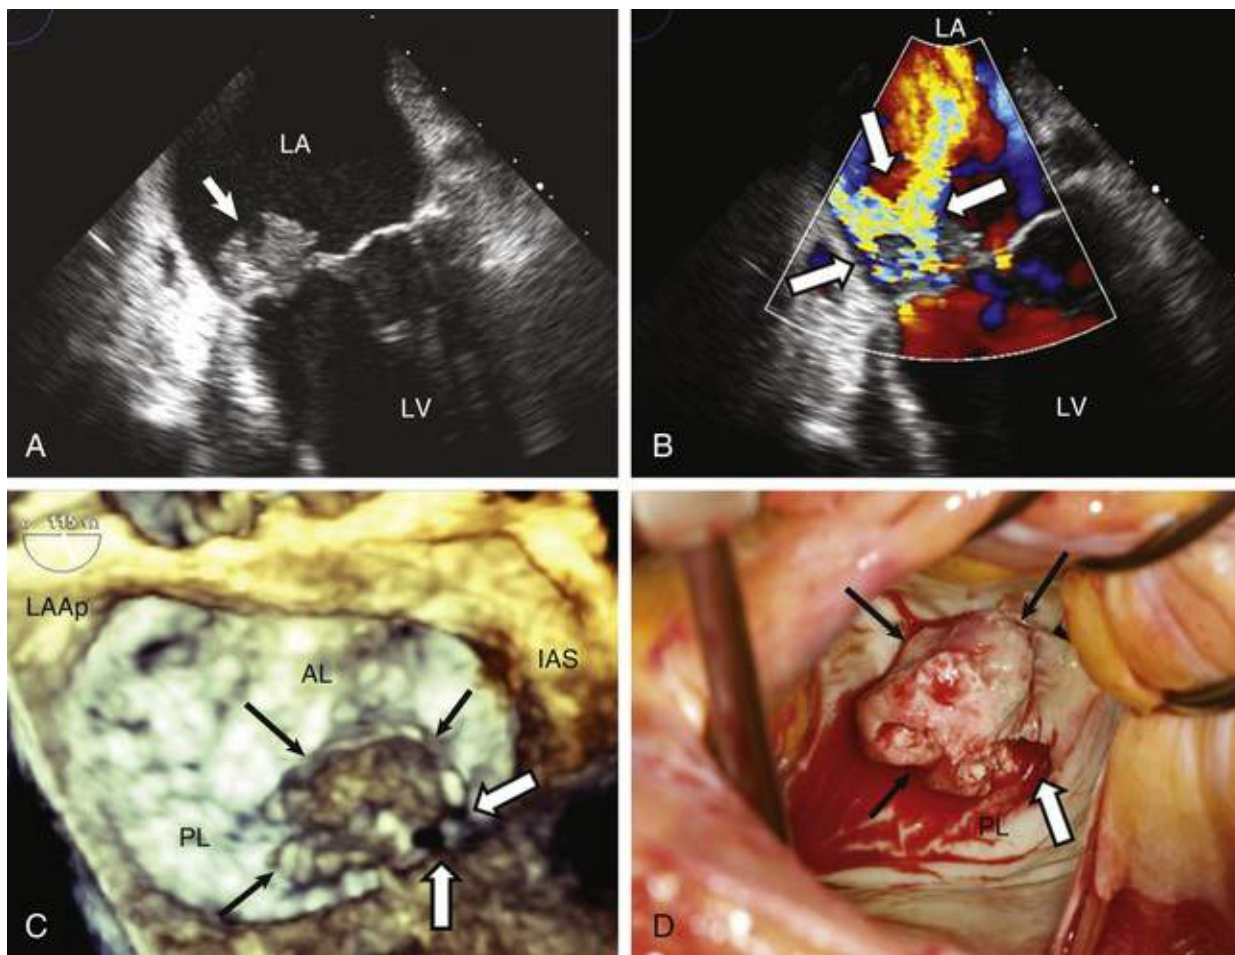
Infective endocarditis involving the mitral valve. A, Transesophageal echocardiography (TEE) image shows a large vegetation (*arrow*) attached to the atrial aspect of the posterior leaflet. B, Color Doppler image demonstrates a complex jet of mitral regurgitation (*arrows*) coursing through the body of the posterior mitral leaflet and vegetative mass, consistent with leaflet perforation. C, Three-dimensional TEE image of the mitral valve, as viewed from the left atrium (*LA*). Large vegetations (*black arrows*) are attached to the medial aspect of the posterior leaflet (*PL*), with perforation (*white arrows*) at the margin of the posteromedial commissure. D, Intraoperative visualization of the mitral valve as viewed from the left atriotomy. The large vegetative mass (*black arrows*) is attached to the posterior leaflet, and the posteromedial perforation (*white arrow*) is confirmed. *AL*, Anterior leaflet; *IAS*, interatrial septum; *LAAp*, left atrial appendage; *LV*, left ventricle.
